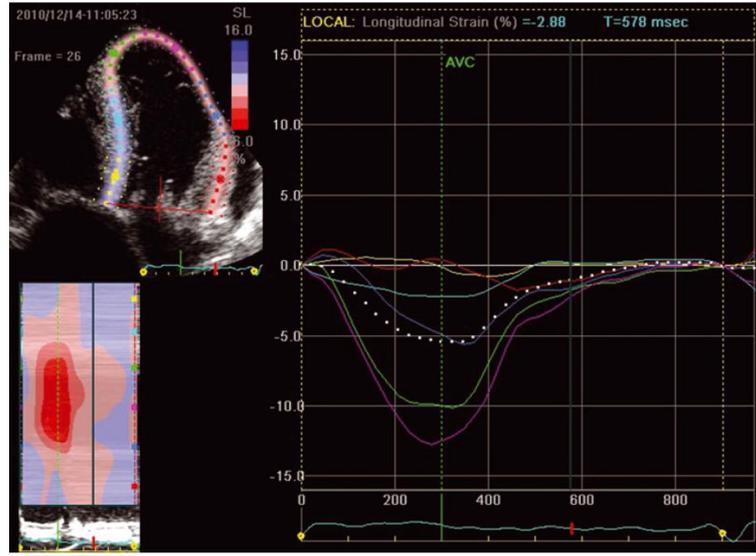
Transthoracic echocardiogram with speckle tracking. The red and yellow lines represent longitudinal motion in the basal segments, whereas the purple and green lines represent apical motion. This shows loss of longitudinal ventricular contraction at the base compared to apex.
